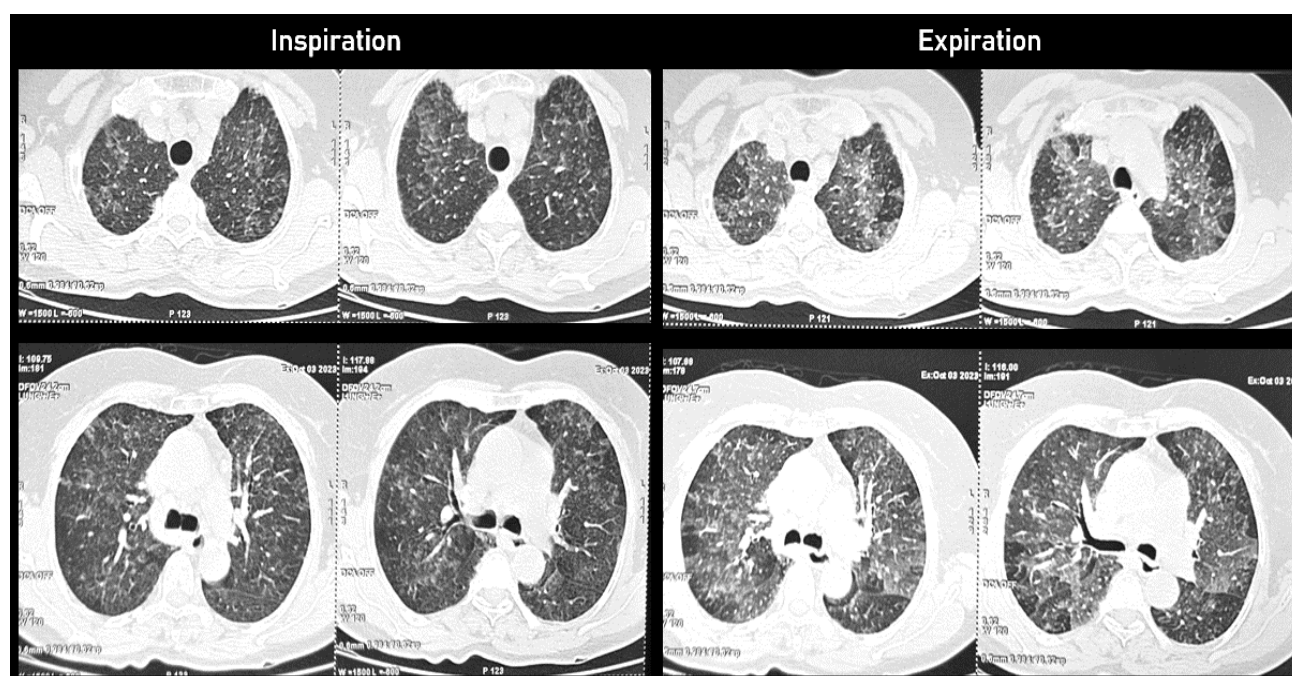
High-resolution computed tomography of Case 1. Inspiratory and expiratory acquisitions show mosaic attenuation, expiratory air trapping, and centrilobular micronodules, consistent with typical nonfibrotic hypersensitivity pneumonitis
